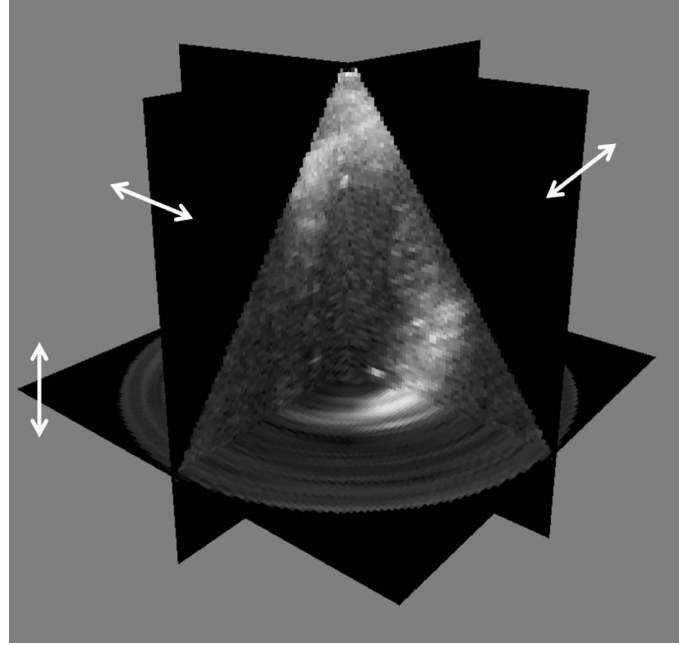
Display of the 3-D echocardiographic image, after reconstruction, using three mobile planes.
